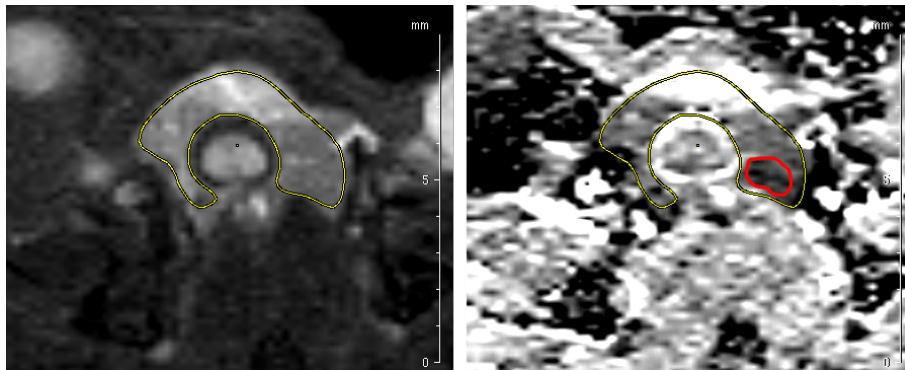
Example of MRI data of a TRAMP prostate. From the T2 weighted MR image (left) the whole prostate could be delimited. From the diffusion weighted images (DWI), and the corresponding map of the ADC, apparent diffusion coefficient (right), allowed the detection of the tumor area (delineated in red) in the left dorsal prostate lobe with a reduced ADC compared to healthy prostate.
